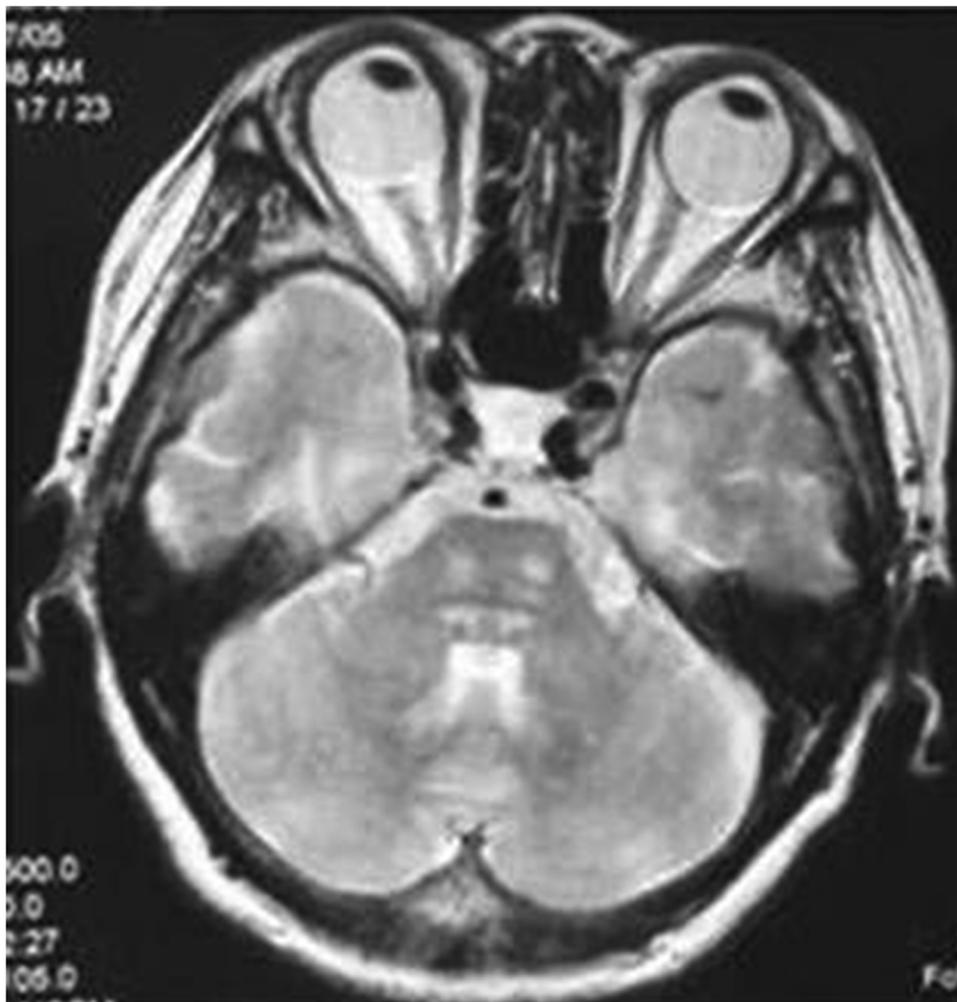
Horizontal T1-weighted image of the head. No structural changes were found in the head and there were no findings of pressure on the trigeminal or glossopharyngeal nerve.
